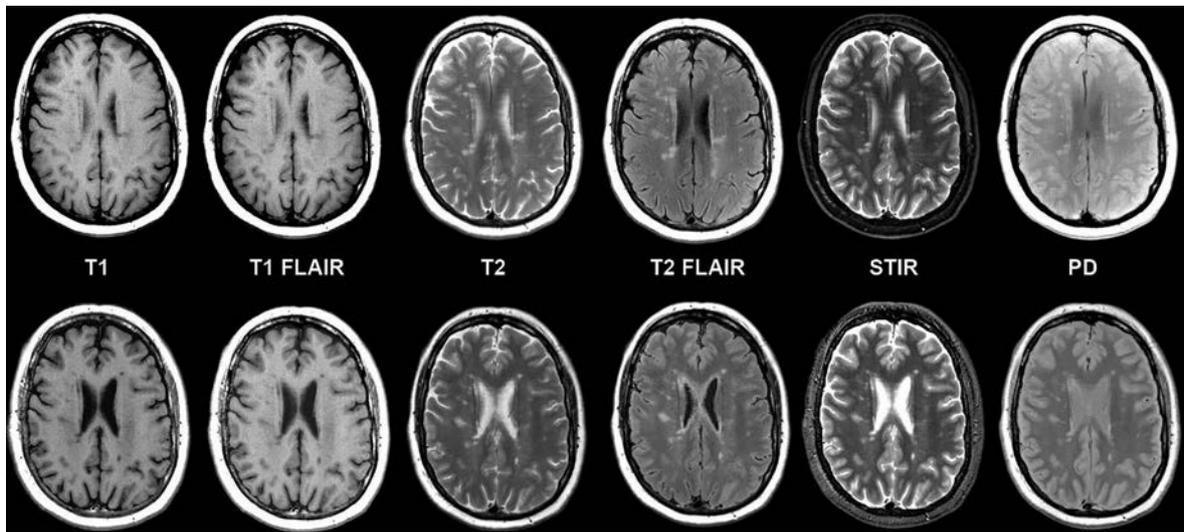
Multiple sclerosis in axial synthetic and conventional 3T MR imaging in a 58-year-old woman. Multifocal demyelinating lesions are apparent within the cerebral white matter; these lesions appear similar on conventional (*upper row*) and synthetic (*lower row*) image sets. A slight misregistration is apparent due to patient motion between the MDME scan (used for synthetic reconstruction, *lower row*) and the comparable conventional scan acquired in the study (*upper row*). While misregistration due to motion can pose challenges in conventional serial acquisitions due to partial section differences in images across contrast views, synthetic reconstruction inherently prevents misregistration across synthetic contrast views.
